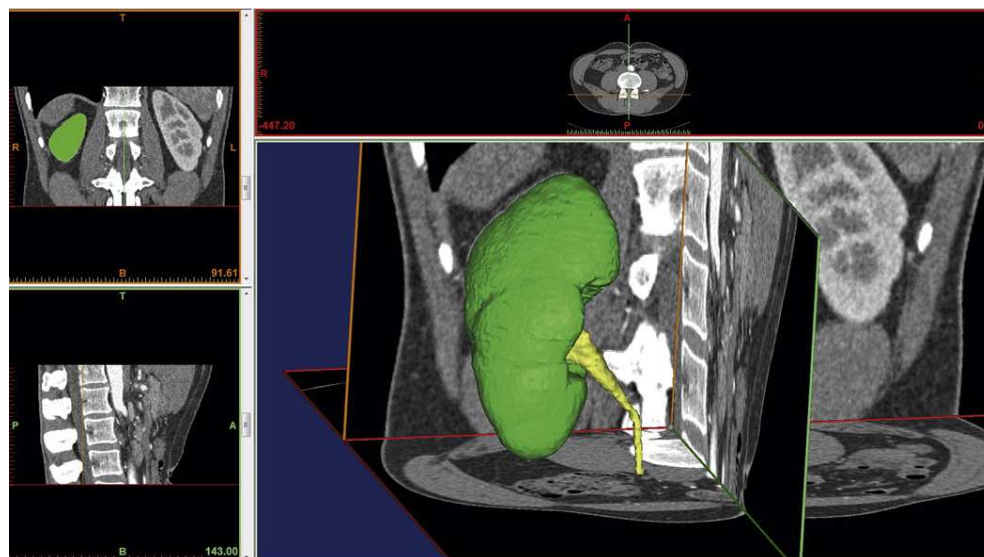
CT structural segmentation of the right kidney. From Weber State University, School of Radiologic Sciences.
